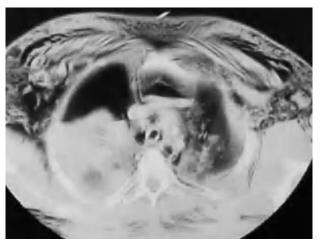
Computed tomography chest scan for case 10. The patient had a traumatic bronchial injury. After being transferred from a referral hospital, the patient underwent surgery without lung resection. Initial treatment in this case was conservative without bronchial repair; however, increased subcutaneous emphysema, traumatic pneumothorax, and nearly complete atelectasis of the right lung made bronchoplasty necessary.
